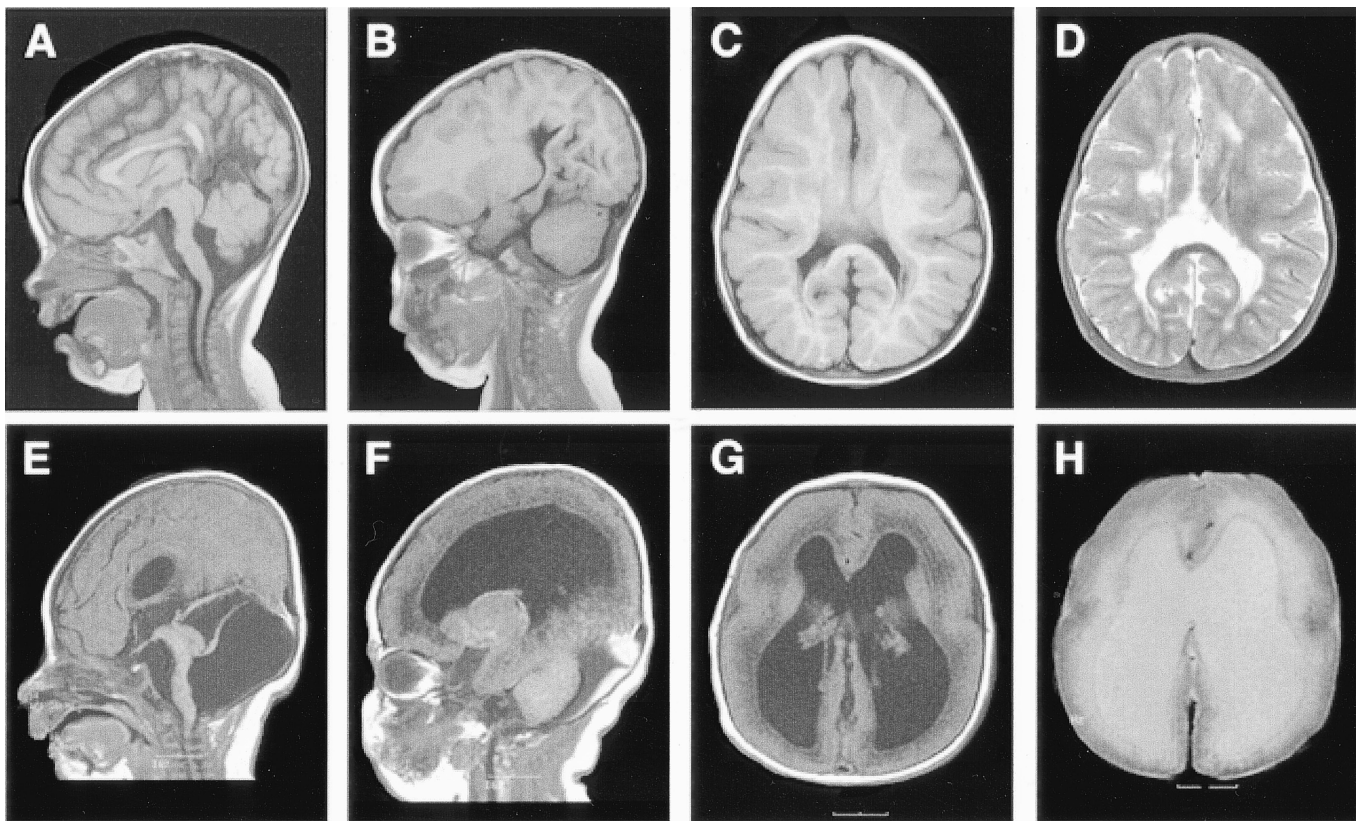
Comparison of MR abnormalities in muscle-eye-brain disease (MEB) (A to D) and Walker-Warburg syndrome (WWS) (E to H). Cranial MR images of patient II-1 (family 18) at age 3 years and patient II-1 (family 12) at age 4 days demonstrate typical MEB and WWS patterns of cobblestone complex. Midline sagittal images (A, E) show an intact although deformed corpus callosum, flat brainstem, and mild cerebellar vermis hypoplasia in MEB (A) compared with a severely hypoplastic corpus callosum, flat brainstem, and severe pancerebellar hypoplasia in WWS (E). Parasagittal images (B, F) show an irregular surface and atypical pachygyria in MEB (B) compared with a pebbled surface resembling lissencephaly in WWS (F). Axial T1-weighted images (C, G) show the same anteroposterior gradient with intermediate (5 to 8 mm) increased thickness of the cortex in MEB (G) compared with an almost smooth surface with no definite gradient, slightly thicker (7 to 10 mm) cortex, and absent or disrupted septum pellucidum in WWS (G). Finally, axial T2-weighted images show patchy increased signal of the white matter in MEB (D) compared with diffuse abnormal signal in WWS (H), although the child with WWS is much younger. The irregular cortical surface and cortical-white matter interface are well seen in both figures, although better in WWS (H).
